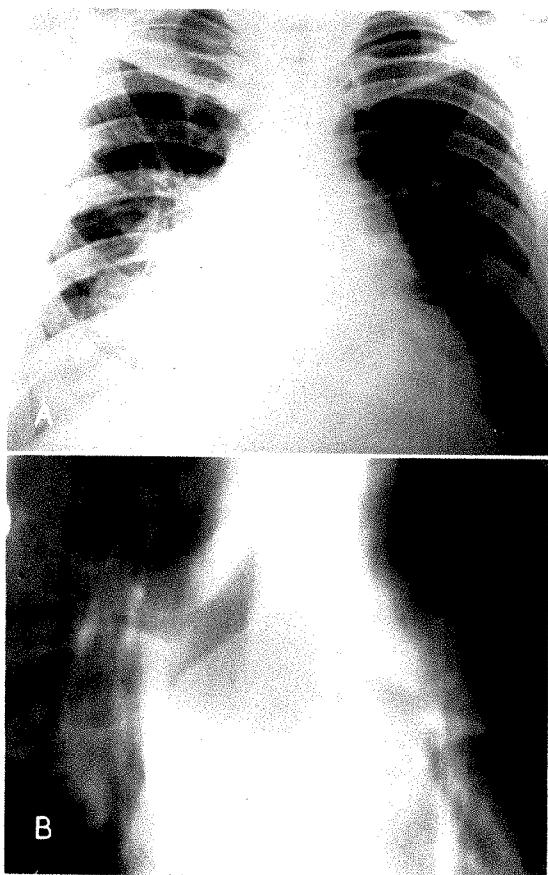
Case v. Mediastinal, endobronchial and parenchymal lymphosarcoma. (A) Conventional chest roentgenogram showing cardiac enlargement and right mediastinal and parenchymal masses. (B) Mediastinal laminagram showing conical narrowing of mainstem bronchus below origin of upper lobe division and segmental atelectasis of lower lobe. Extrinsic pressure is evident on left mainstem bronchus.
